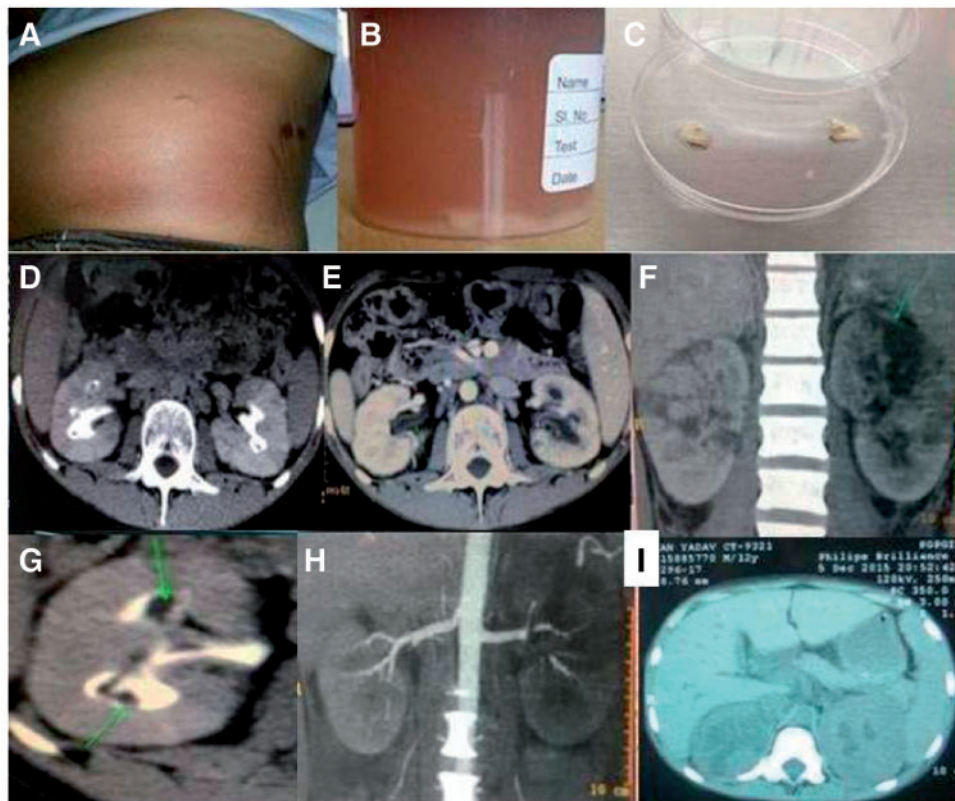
Clinical findings in IRM patients. (A) Patient's abdomen shows erythema and subcutaneous edema of the flank region. (B) Urine sample: gross hematuria with white flakes containing papillary tissue and fungus settled at the bottom. (C) Mucor bezoars passed in the urine of an IRM patient complaining of abdominal colics. (D) Non-contrast CT of the abdomen in the coronal plane at the level of the kidneys shows bilateral bulky kidneys with parenchymal hypodensities. (E) Contrast CT of the abdomen in the axial plane at the level of the kidneys shows bilateral bulky kidneys with enhancing thickening of the wall of the renal pelvis. (F) Contrast CT of the abdomen in the coronal plane shows bilateral bulky kidneys with multiple nonenhancing areas with preserved normal subcapsular parenchyma (Rim sign). (G) Contrast CT of the abdomen (excretory phase) in the coronal plane shows the right kidney demonstrating a filling defect in the calyceal system. (H) CT angiography (reformatted in the coronal plane) shows normal main renal arteries with attenuated segmental branches in the region of nonenhancing areas suggestive of vascular invasion. (I) Noncontrast CT of the abdomen shows bilaterally enlarged kidneys with irregular, nonhomogeneous, hypodense areas within the renal parenchyma and perinephric fat stranding.
